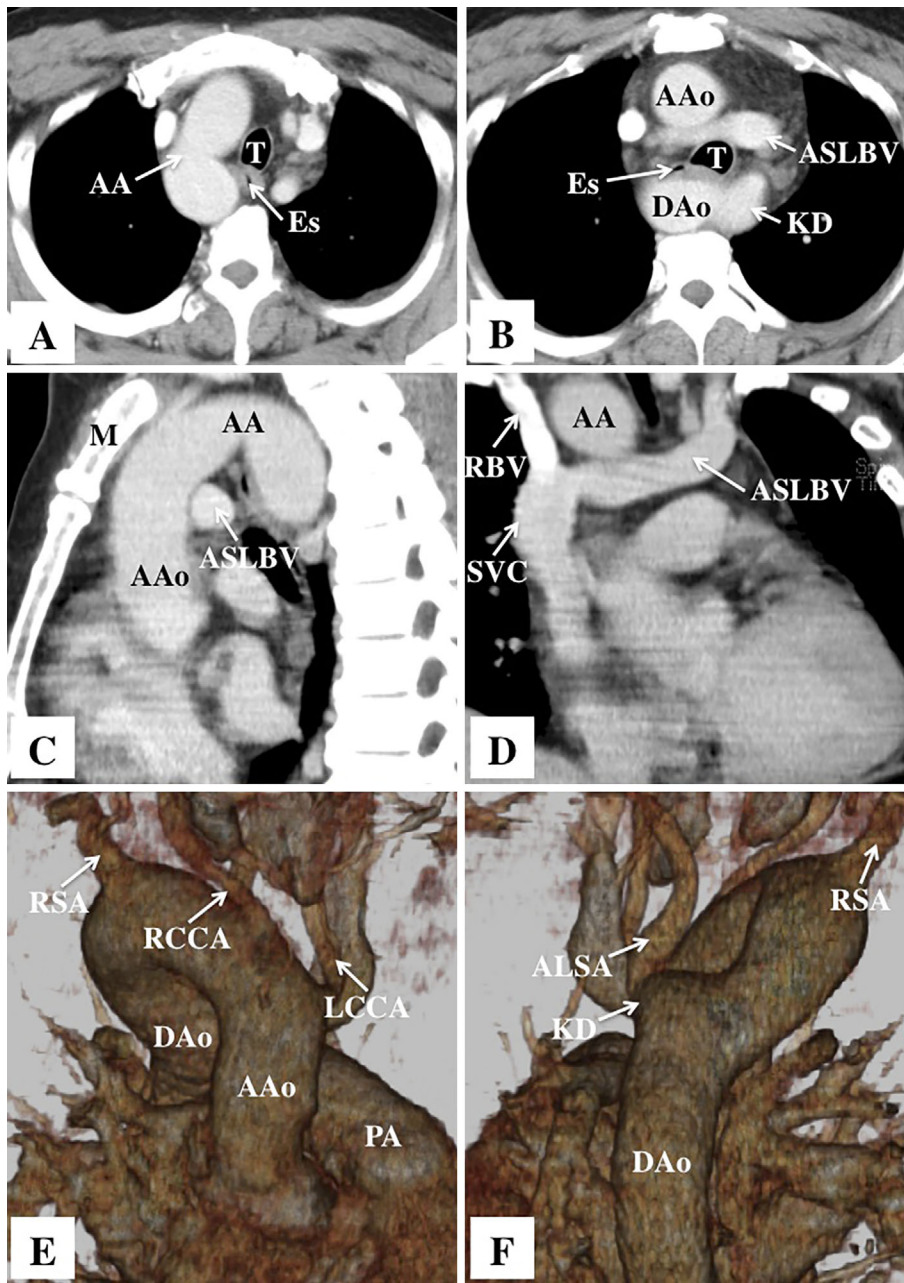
Axial views (A and B), multi-planar reconstruction views (C and D), and three-dimensional views (E and F) obtained using contrast-enhanced thoracic computed tomography. A: The aortic arch is right-sided. B: The trachea and esophagus are surrounded by both the descending aorta and Kommerell's diverticulum. An anomalous subaortic left brachiocephalic vein passes anterior to the trachea. C: A sagittal view of the thorax shows that the top of the aortic arch reaches the superior border of the manubrium sterni. D: A coronal view of the thorax shows that the anomalous subaortic left brachiocephalic vein passes under the aortic arch and joins the right brachiocephalic vein. E: An anterior view of the right aortic arch shows the left common carotid artery arising as the first branch of the aorta, followed by the right common carotid and right subclavian artery. F: A posterior view of the right aortic arch shows an aberrant left subclavian artery arising from Kommerell's diverticulum. AA: aortic arch, T: trachea, Es: esophagus, AAo: ascending aorta, DAo: descending aorta, ASLBV: anomalous subaortic left brachiocephalic vein, KD: Kommerell's diverticulum, M: manubrium sterni, RBV: right brachiocephalic vein, SVC: superior vena cava, RSA: right subclavian artery, RCCA: right common carotid artery, LCCA: left common carotid artery, mPA: main pulmonary artery, ALSA: aberrant left subclavian artery
